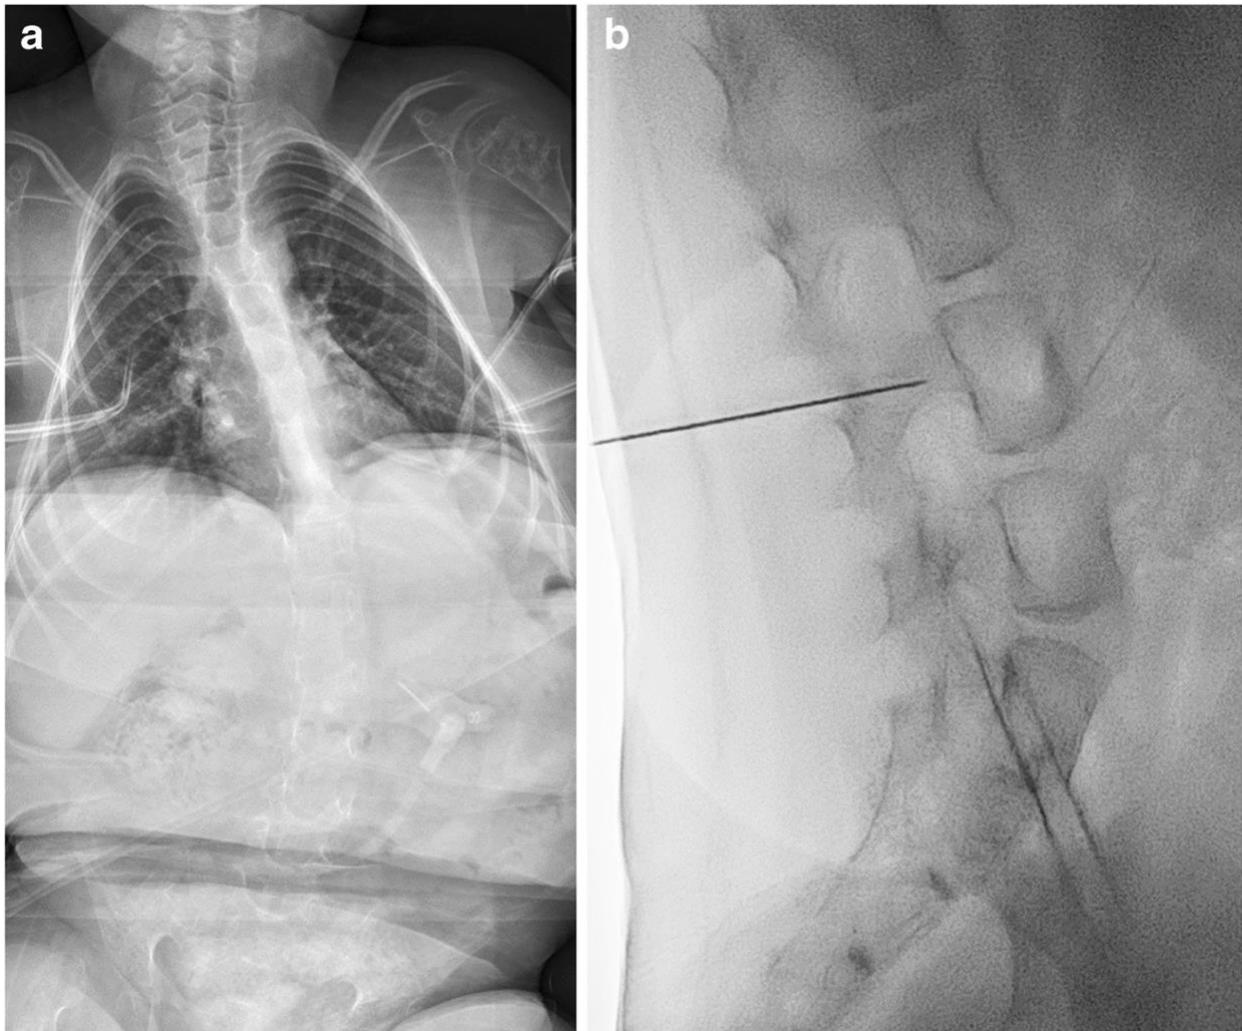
Spinal muscular atrophy type 2 in an 8-year-old boy. a Anteroposterior diagnostic radiograph demonstrates thoracolumbar scoliosis and neuromuscular disease. b Lateral fluoroscopic image demonstrates spinal needle tip positioned in the subarachnoid space at L3-L4 via an interspinous approach. Note true lateral projection using vertebral bodies and neural foramina as internal landmarks
